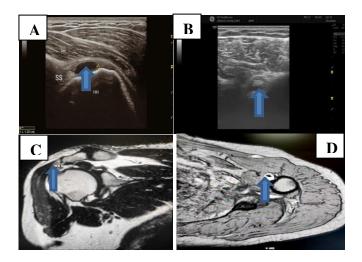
Male patient 49years old with full-thickness tear of supraspinatus tendon; (A) & (B) US: shows hypoechoic area representing distortion of tendon fibers with gap defect 12mm with bicipital tendinitis. (C) &(D) MRI: coronal T2WI sequence shows abnormal hyperintense signal intensity of full thickness tear with bicipital tendinitis.
